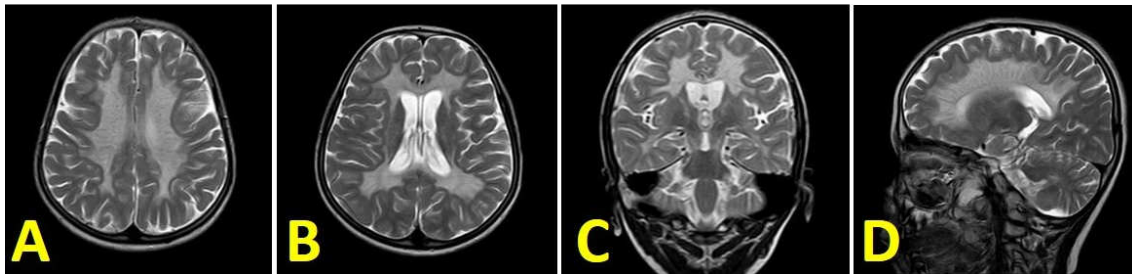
MRI - FLAIR axial (a and b) and coronal (c and d)
